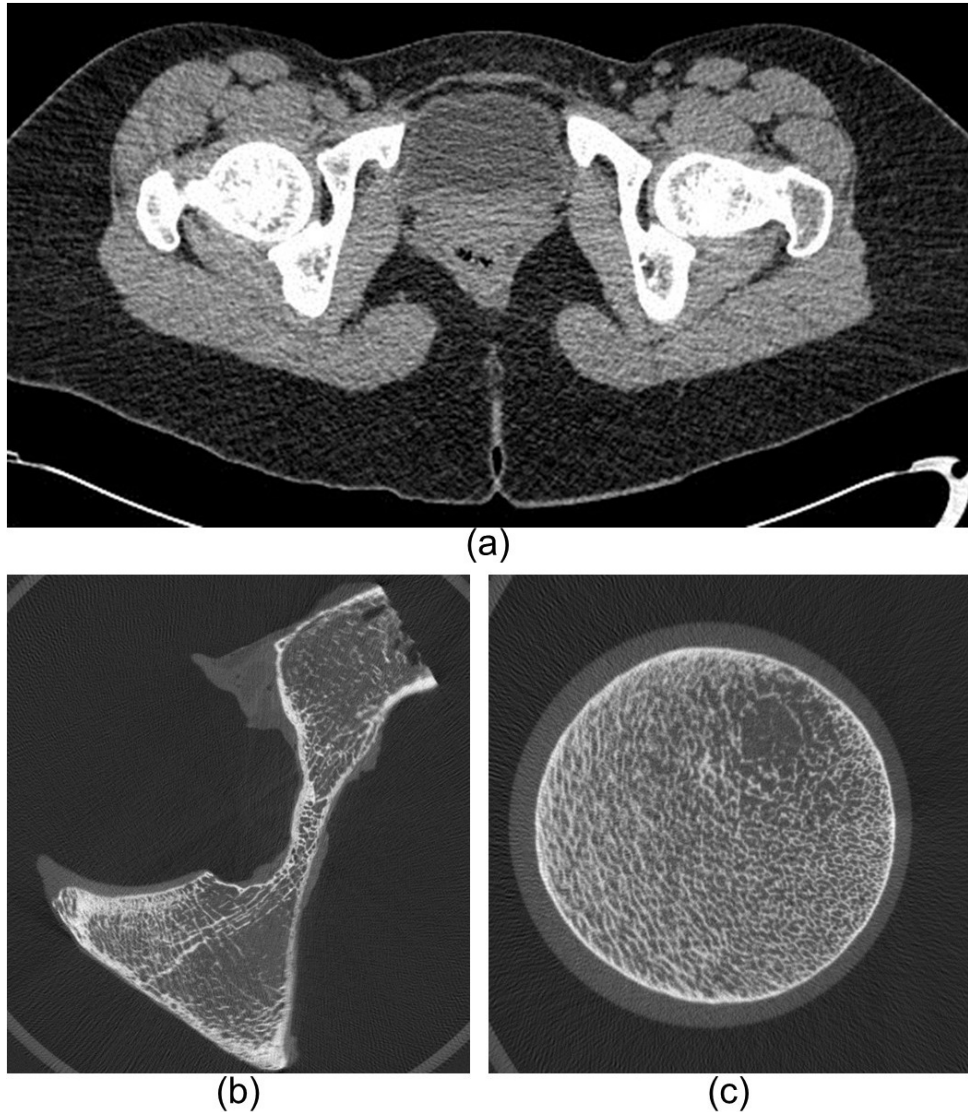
Examples of slices from CT scans:
